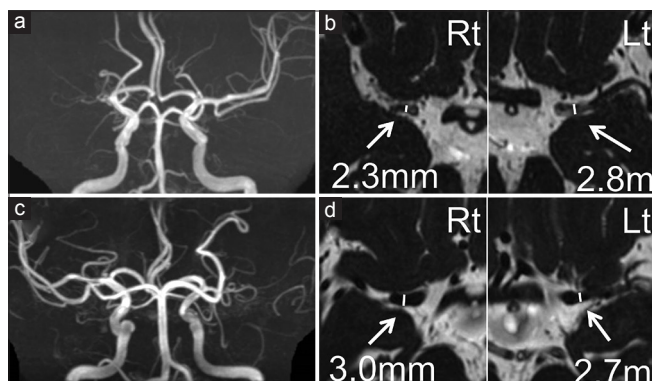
Representative cases are presented. MRA (a and c) and FIESTA images (b and d) of a 70-year-old man with *RNF213* variant (a and b) and of a 72-year-old woman without *RNF213* variant (c and d). Outer diameters of the bilateral MI are shown. >50% stenosis or occlusion cases on MRA were included and the outer diameter of MI was measured at the greatest minor axis in the proximal portion on axial FIESTA MRI. Rt indicates right side; Lt, left side
